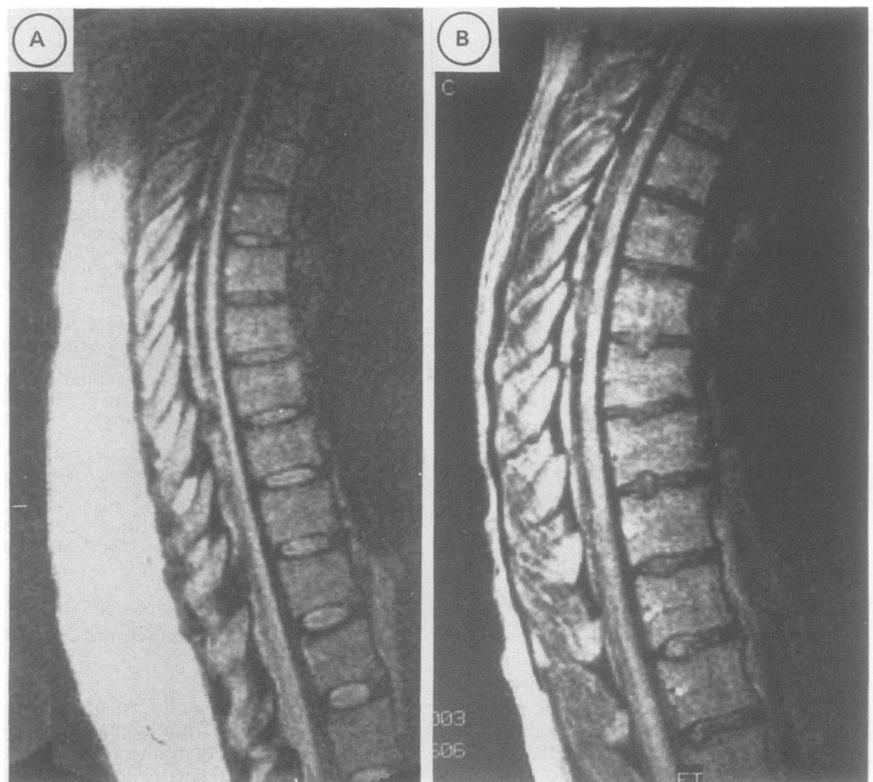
Figure The MRI on the left shows diffuse high signal with atrophy of the thoracic cord in TSP. The right shows the patchy high signal typically seen in MS. ($SE_{1500/80}$ 5 mm sagittal slices).
